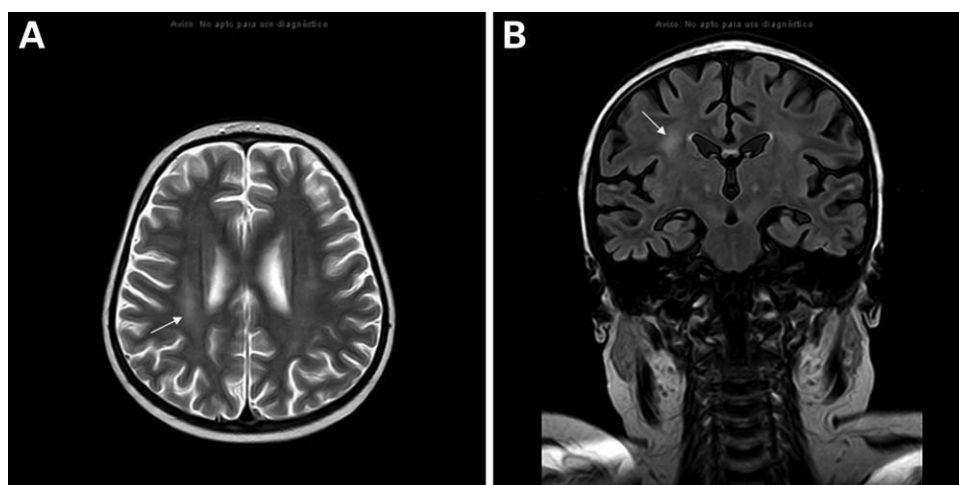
MR imaging findings six weeks after neurologic event. Axial T2 (A) and coronal FLAIR (B) sequences show deep and periventricular white matter hyperintensity, especially in the right hemisphere.
